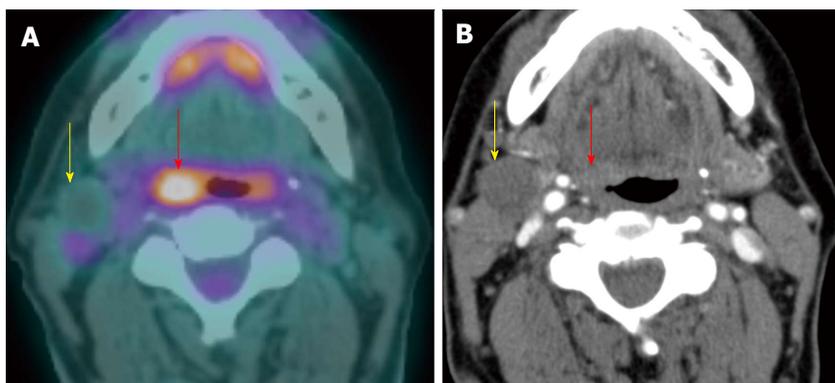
Hypometabolic necrotic lymph node. A T1N1M0 right glossopharyngeal sulcus squamous cell carcinoma (red arrow) is FDG avid on positron emission tomography/computed tomography (PET/CT) (A). There is a 1.7-cm necrotic right level II a lymph node seen on contrast-enhanced CT (B). The necrotic lymph node is hypometabolic and may potentially cause a false negative result if the CT portion of the PET/CT or corresponding contrast-enhanced CT were not correlated.
